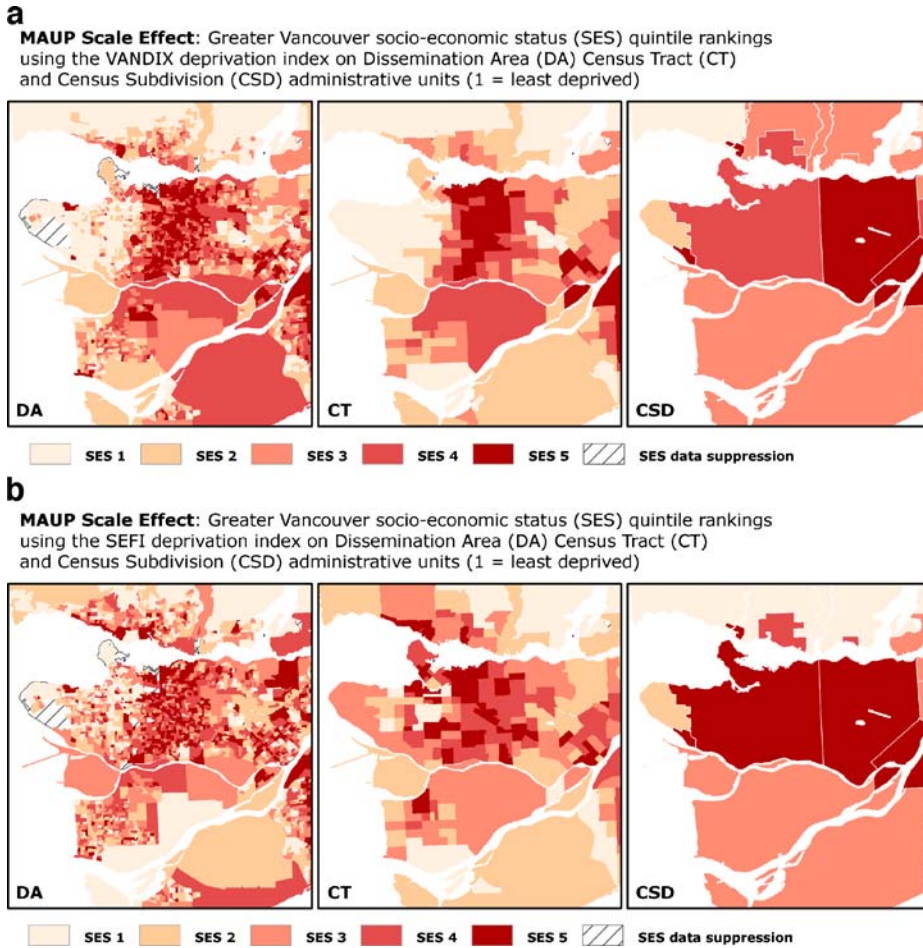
(a) MAUP scale effect: Greater Vancouver socioeconomic status (SES) quintile rankings using the VANDIX deprivation index on Dissemination Area (DA), Census Tract (CT), and Census Subdivision (CSD) administrative units (1 = least deprived); (b) MAUP scale effect: Greater Vancouver socioeconomic status (SES) quintile rankings using the VANDIX deprivation index on Dissemination Area (DA), Census Tract (CT), and Census Subdivision (CSD) administrative units (1 = least deprived).
